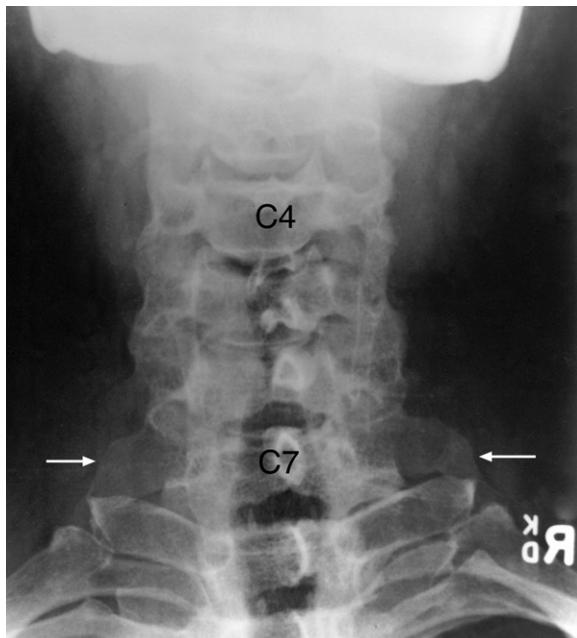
Cervical spine anteroposterior plain X-ray image. Note the small bilateral bony cervical ribs (arrows).
